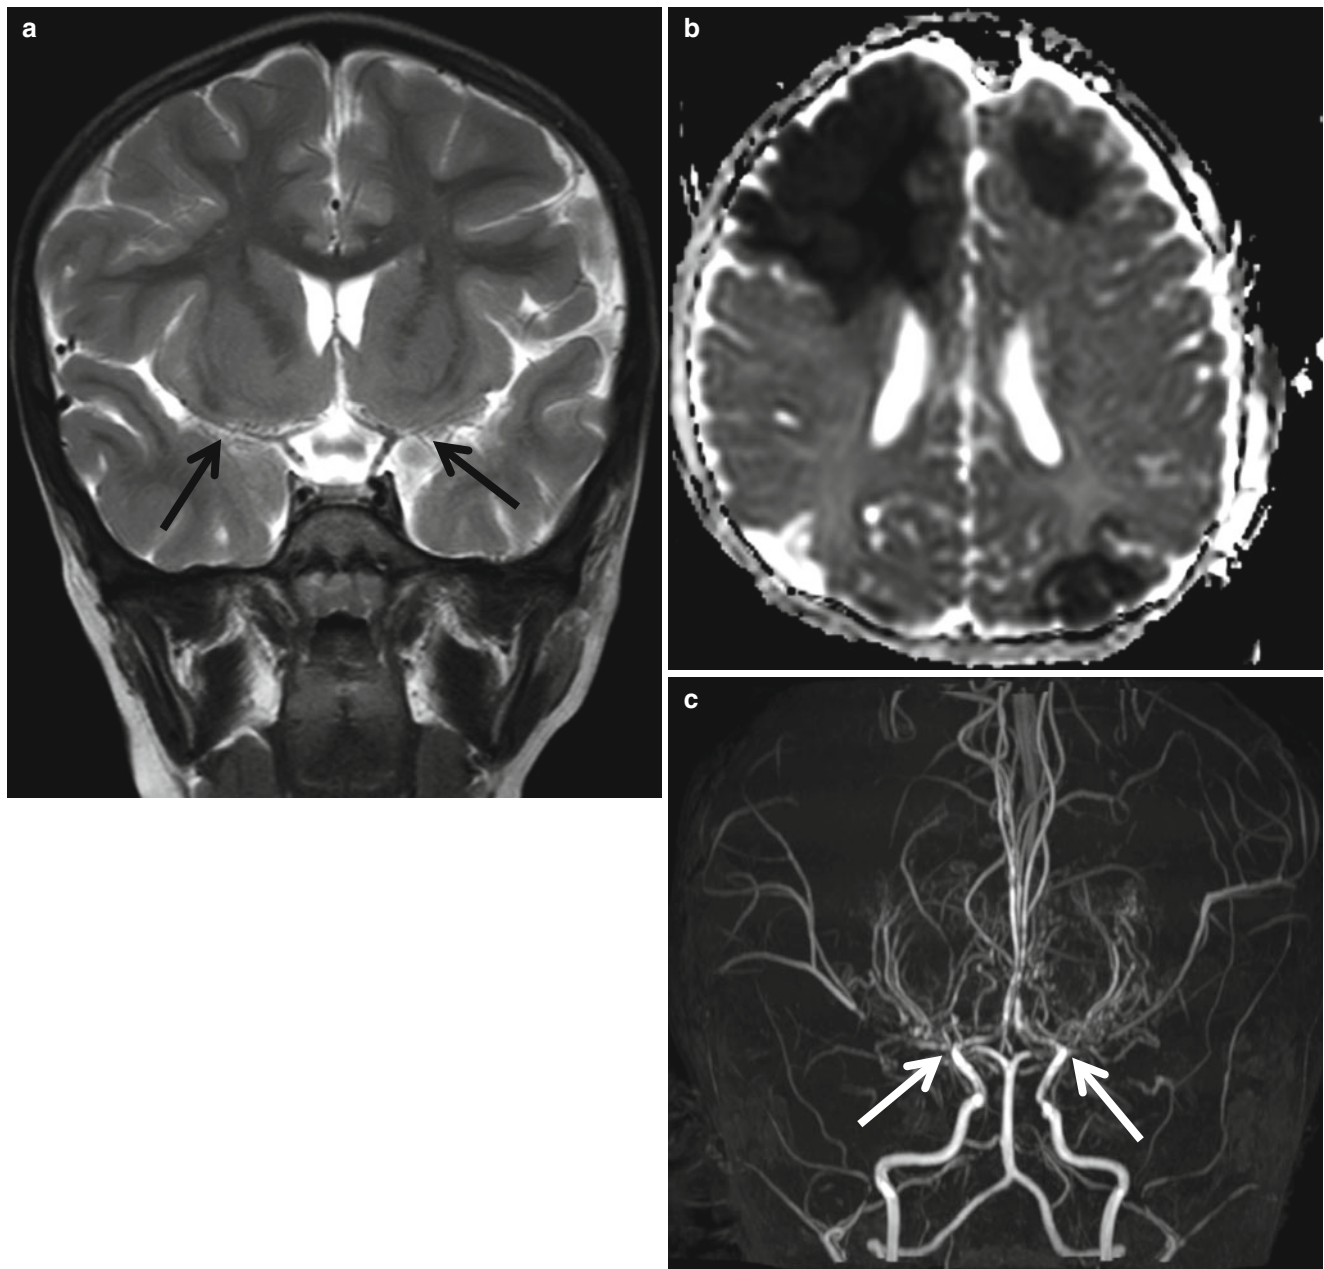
Acute watershed area infarct in moyamoya disease. (a) T2-weighted coronal image obtained on the second day of stroke shows attenuated bilateral MCA (*arrows*). (b) ADC map reveals acute
